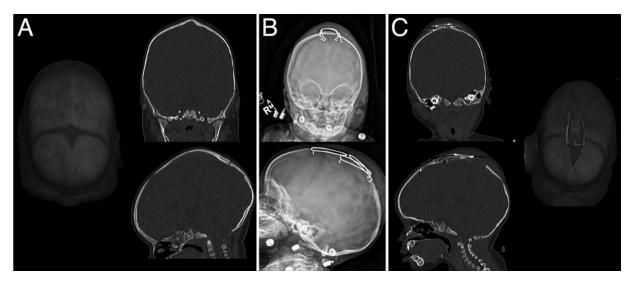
Pre- and postoperative imaging of the same patient as in Fig. 1. A: Preoperative 3D CT coronal (*upper right*) and sagittal sections (*lower right*) and 3D-CT reconstruction (*left*). B: Coronal (*upper*) and sagittal (*lower*) views of the immediate postoperative cephalogram. C: Postoperative 3D-CT coronal (*upper left*) and sagittal sections (*lower left*), and 3D reconstruction showing spring positions (*right*).
